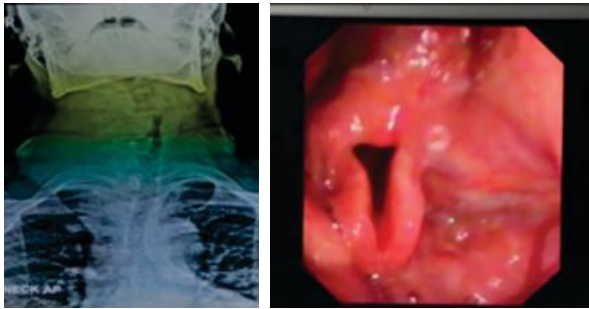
a) X-ray neck showing deviation of trachea b) NPL showing, a folded epiglottis, bilateral aryepiglottic fold collapse
